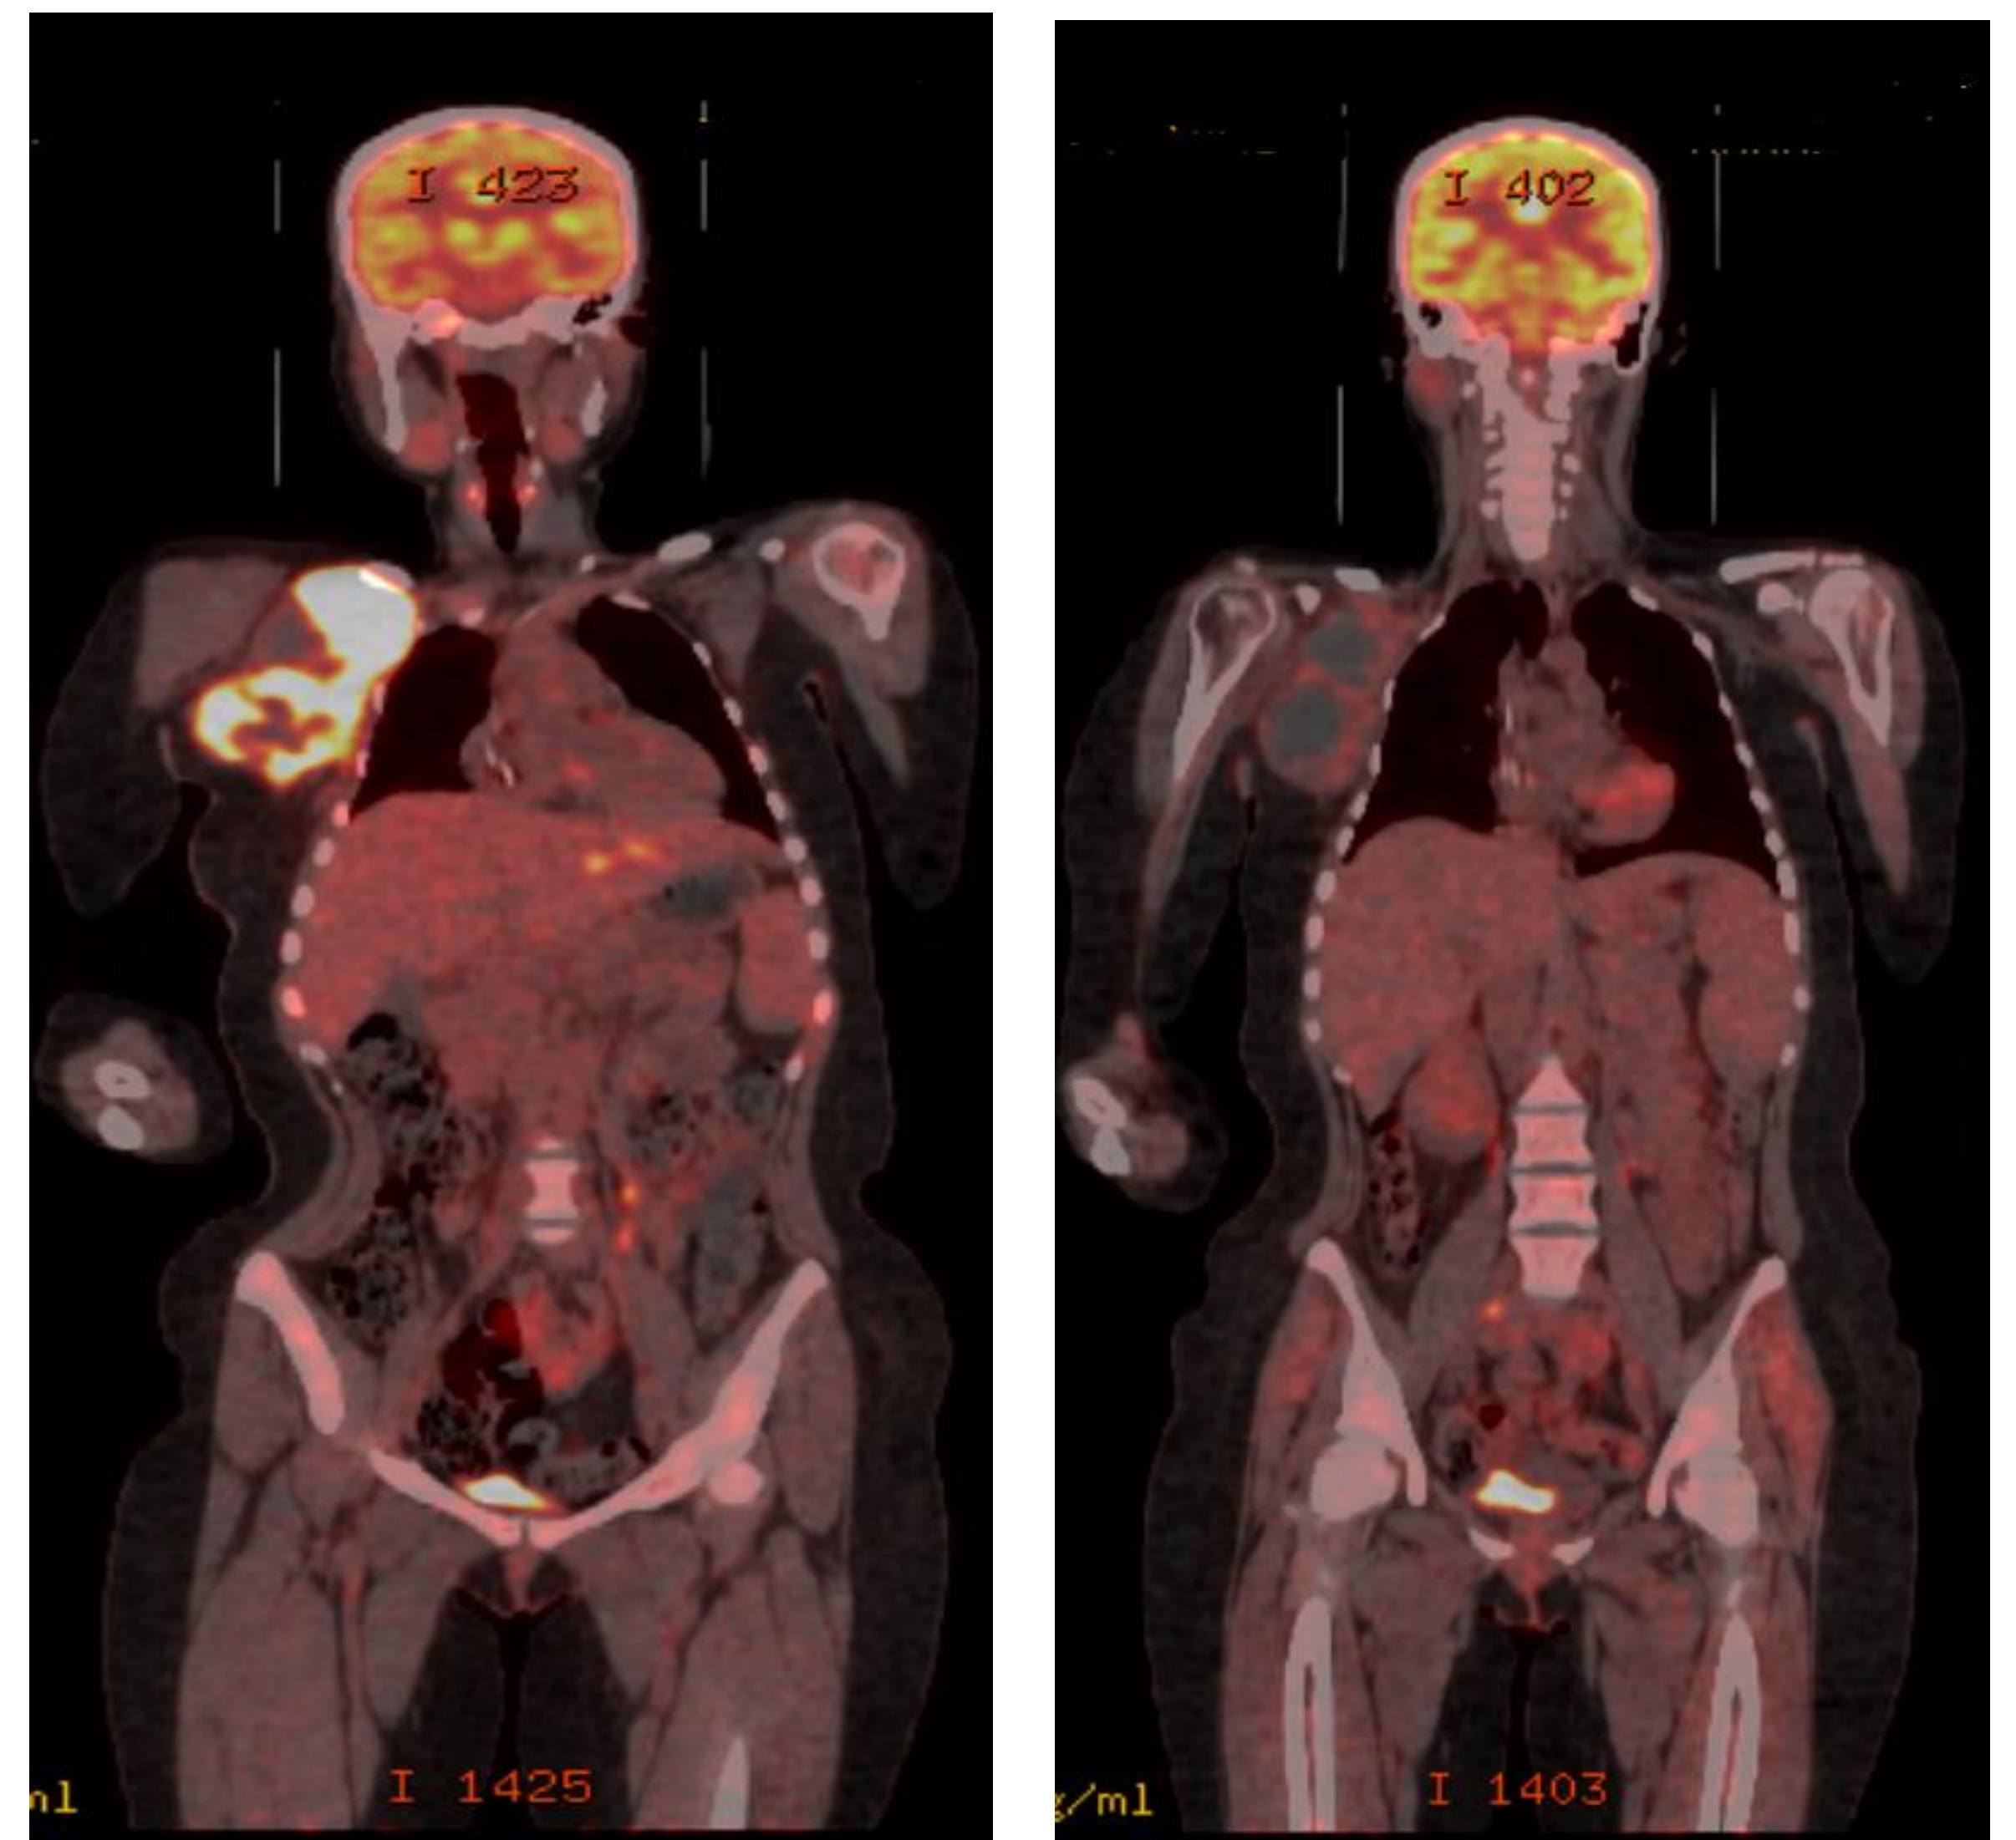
pre-treatment FDG-PET imaging; 1b. post-treatment FDG-PET imaging
